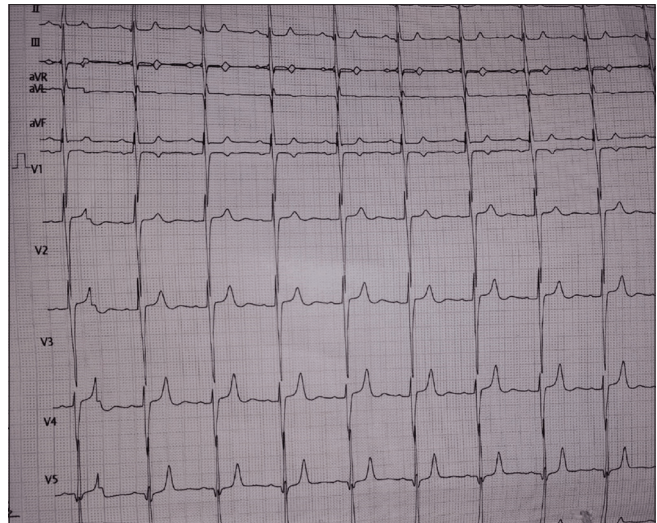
Echocardiography demonstrating T-wave inversion
